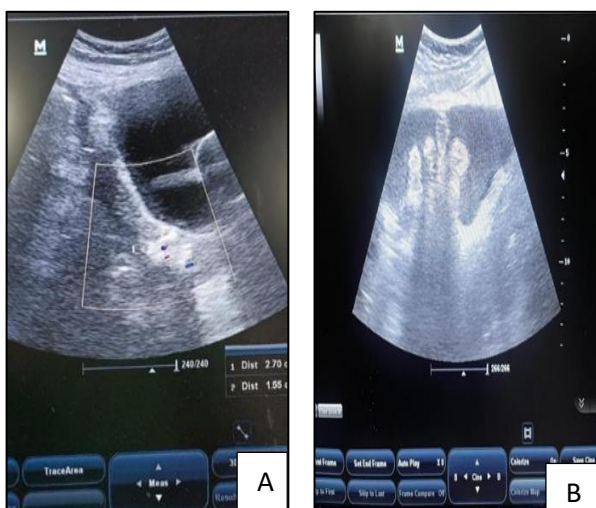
(A and B): Show the ultrasound images showing heteroechoic foci inside the uterine cavity and gross free fluid abdomen, respectively.
